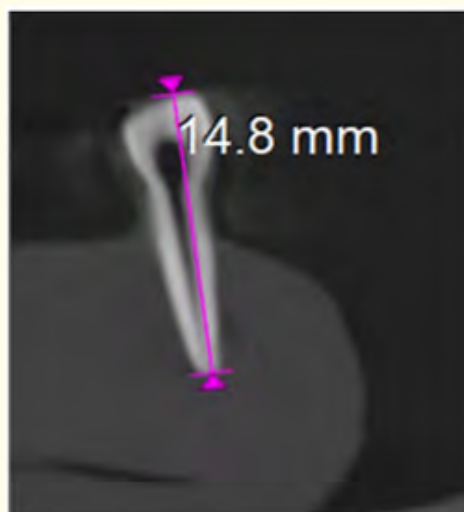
Working length determination using CBCT scan technique.
